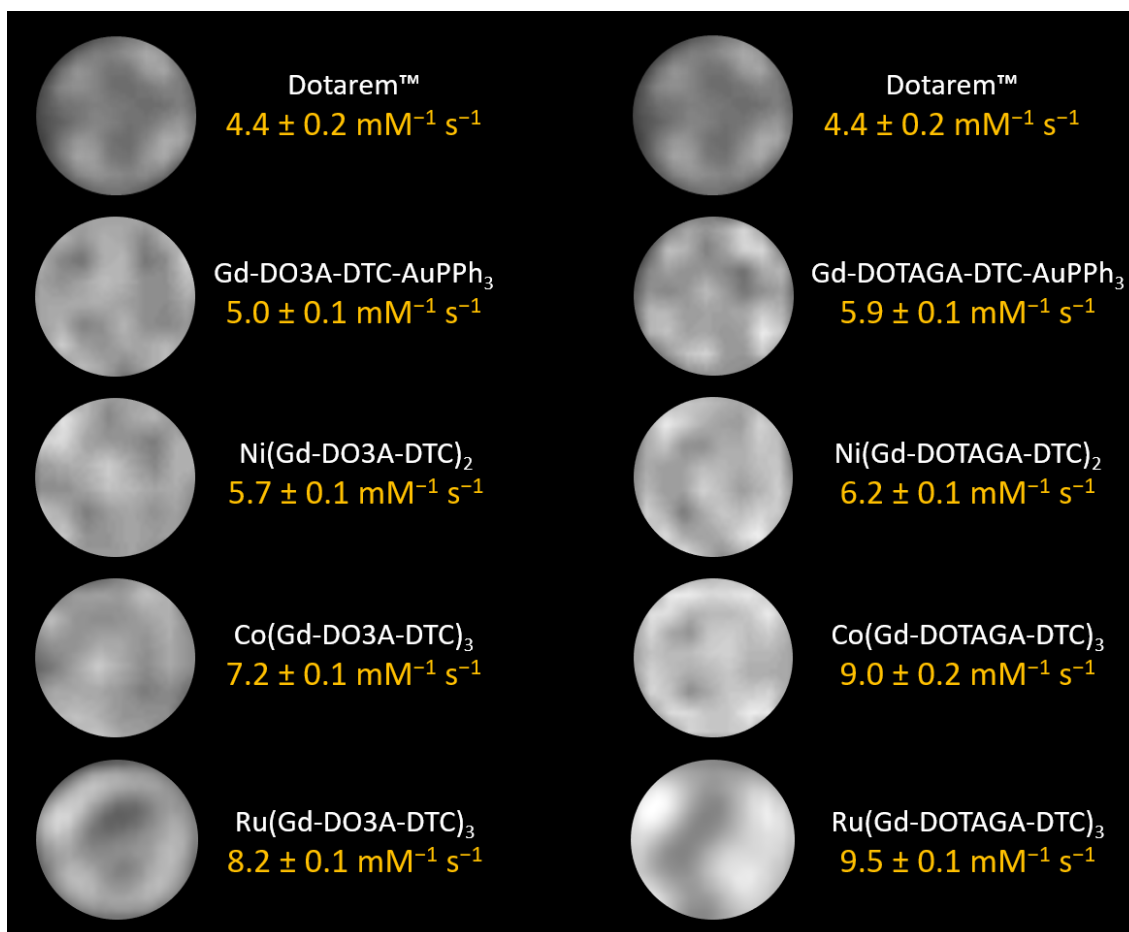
MR images and relaxivity values of the metallostar complexes and Dotarem® (1.5 T, 25 °C,  $[\text{Gd}^{3+}] = 0.1 \text{ mM}$ ).
